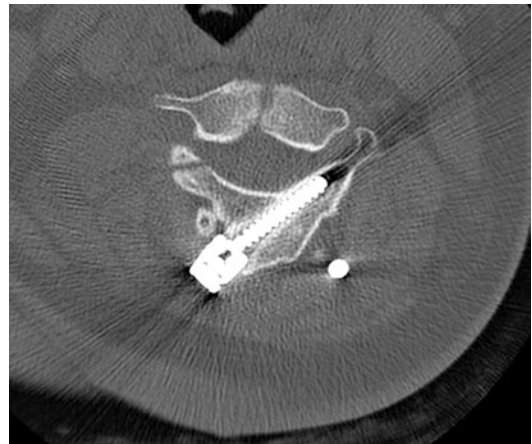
Postoperative CT analysis of C2 intralaminar screw position depicting containment and appropriate length and position
